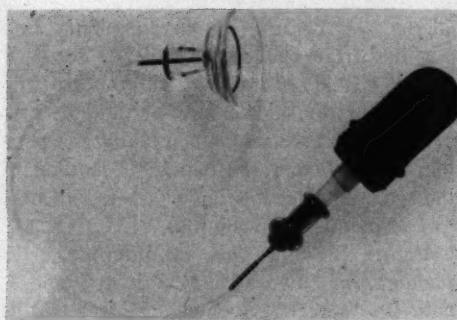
(Worst and Otter). The roentgen reference contact lens. It has radiopaque parts: a central metal capillary (also for applying the low vacuum) and a limbal ring. The lens is connected to a suction bulb by means of a flexible polyvinyl-chloride tube.
